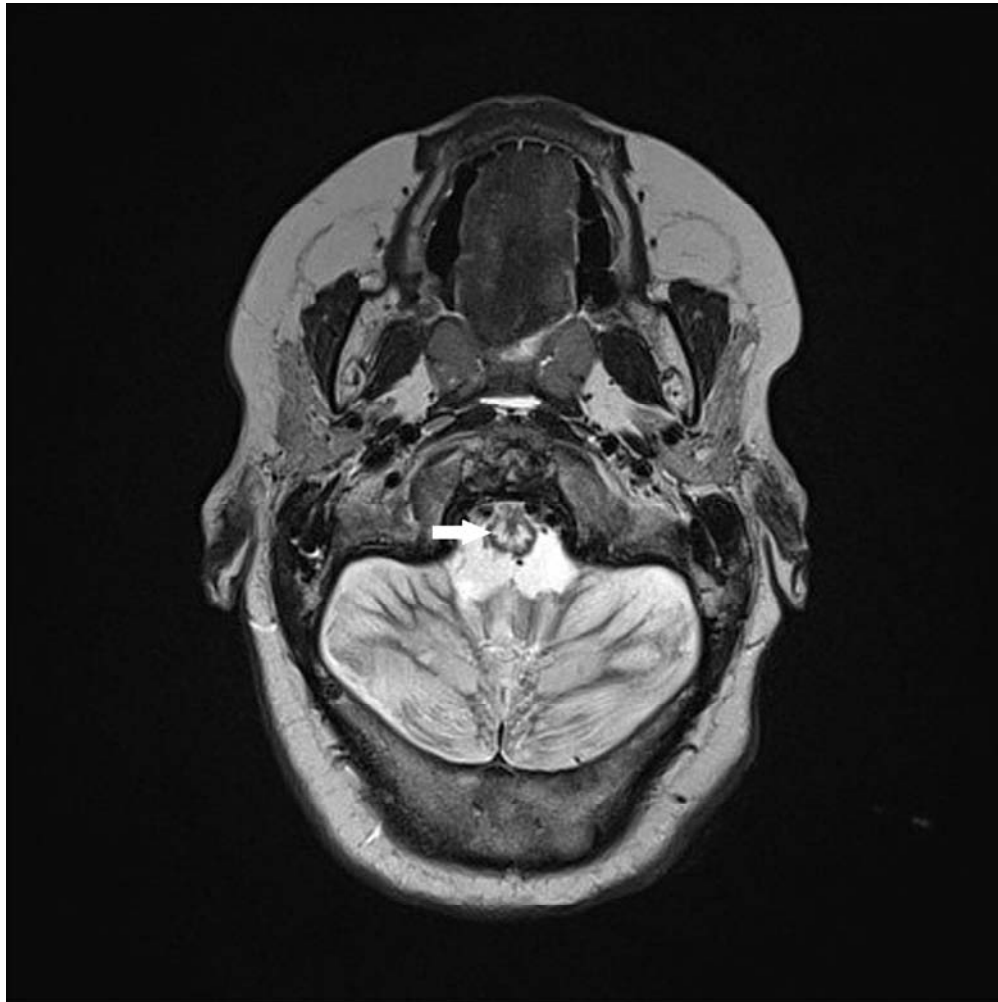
Cerebellar damage and brainstem atrophy with areas of chronic gliosis with Wallerian degeneration at the level of the pons and medulla oblongata. Fig 1A: Sagittal T2-weighted MRI image. Large arrow: pons; small arrow: medulla oblongata. Fig 1B: Axial T2-weighted MRI image, arrow: medulla oblongata. 99x99mm (300 x 300 DPI)
